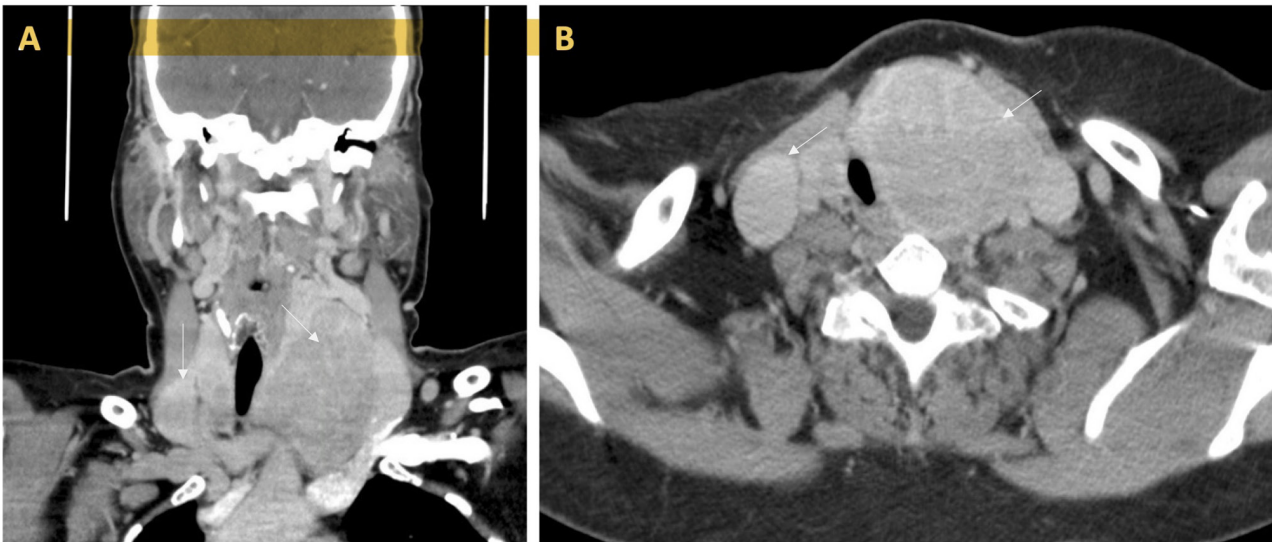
Computed tomography of the head and neck for a 47-year-old female with anaplastic thyroid cancer, showing a large thyroid mass measuring 5.4x6.2x7.7 cm shifting the trachea to the right side and extending inferiorly. (A) Axial and (B) coronal views. Arrows indicate the mass of surrounding tissue.
